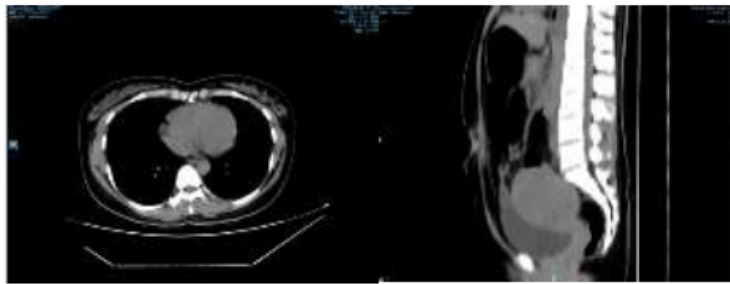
Contrast-enhanced abdominal computed tomography
